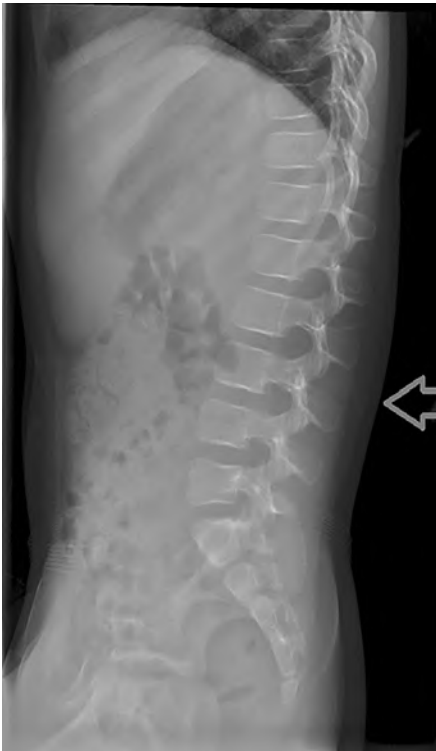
Lateral radiograph of the lumbar spine with noted subcutaneous edema and soft tissue swelling noted by the arrow.
